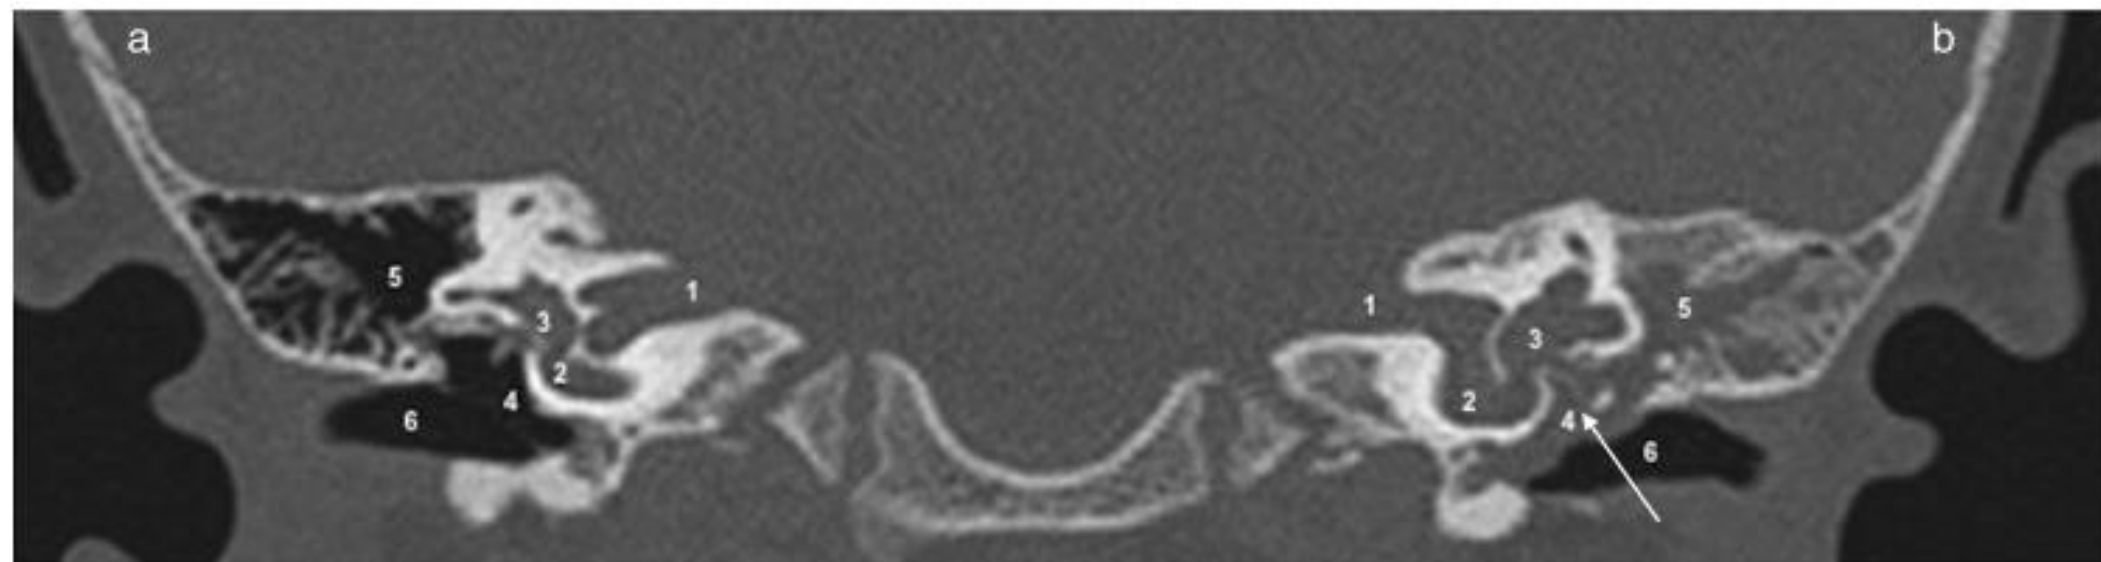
High-resolution computed tomography of the head at the level of the temporal bones, coronal view. Left cochleovestibular malformation (incomplete partition type I, arrow) with communicating internal auditory canal (absent cribriform area), cystic cochlea and middle ear; note the oval window fistula through the dysplastic stapes' footplate, the tympanic cavity and mastoid filled with cerebrospinal fluid, the tympanic membrane bulging into the external auditory canal and the dysplastic vestibule and lateral semi-circular canal. Normal right ear anatomy. (a) Right ear; (b) left ear. 1, internal auditory canal; 2, cochlea; 3, vestibule at the level of the oval window (stapes' footplate) and lateral semicircular canal; 4, tympanic cavity; 5, mastoid; 6, external auditory canal.
